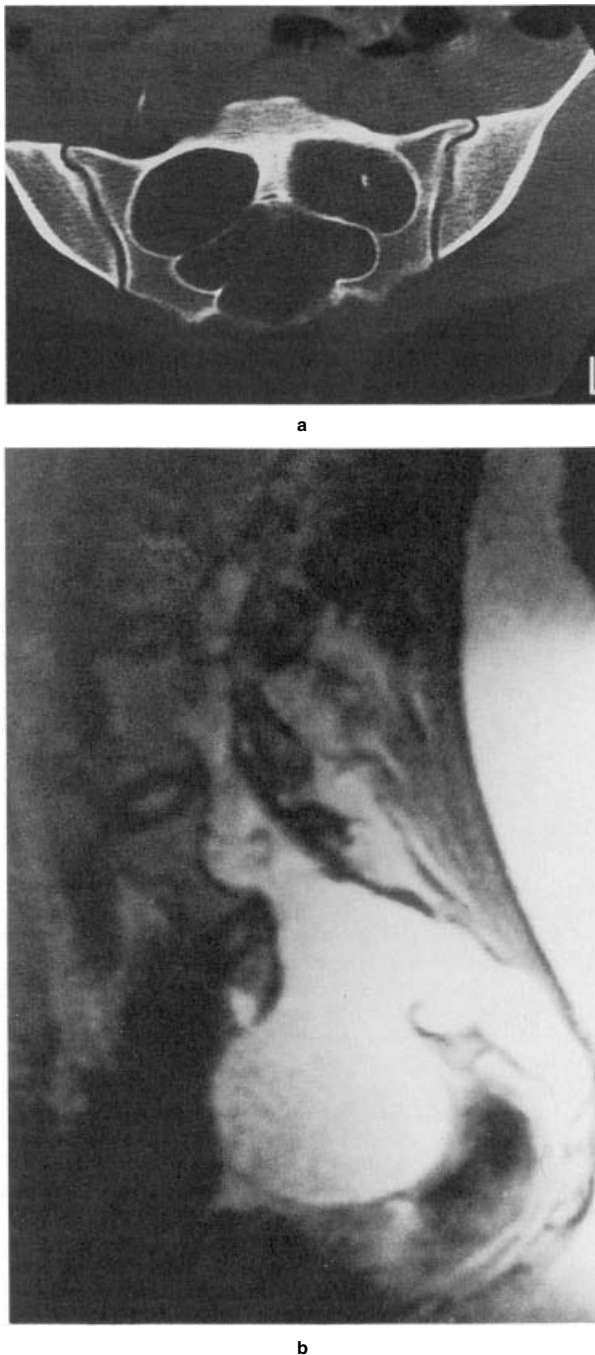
Dural ectasia in Marfan syndrome. a: An axial CT scan of L5, showing marked bony erosion and dilatation of the central spinal canal and the two lateral neural foramina. The scan is oriented with the dorsal surface down. b: A myelogram of the lumbar spine showing both dilatation of the spinal canal and a large anterior pseudomeningocele. The radiograph is oriented with the head up and the dorsal surface to the right.
